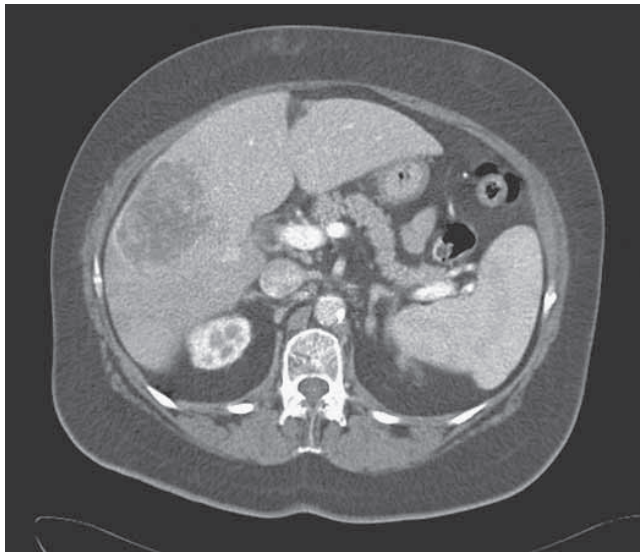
Computed tomographic scan shows a mass-forming intrahepatic cholangiocarcinoma.
